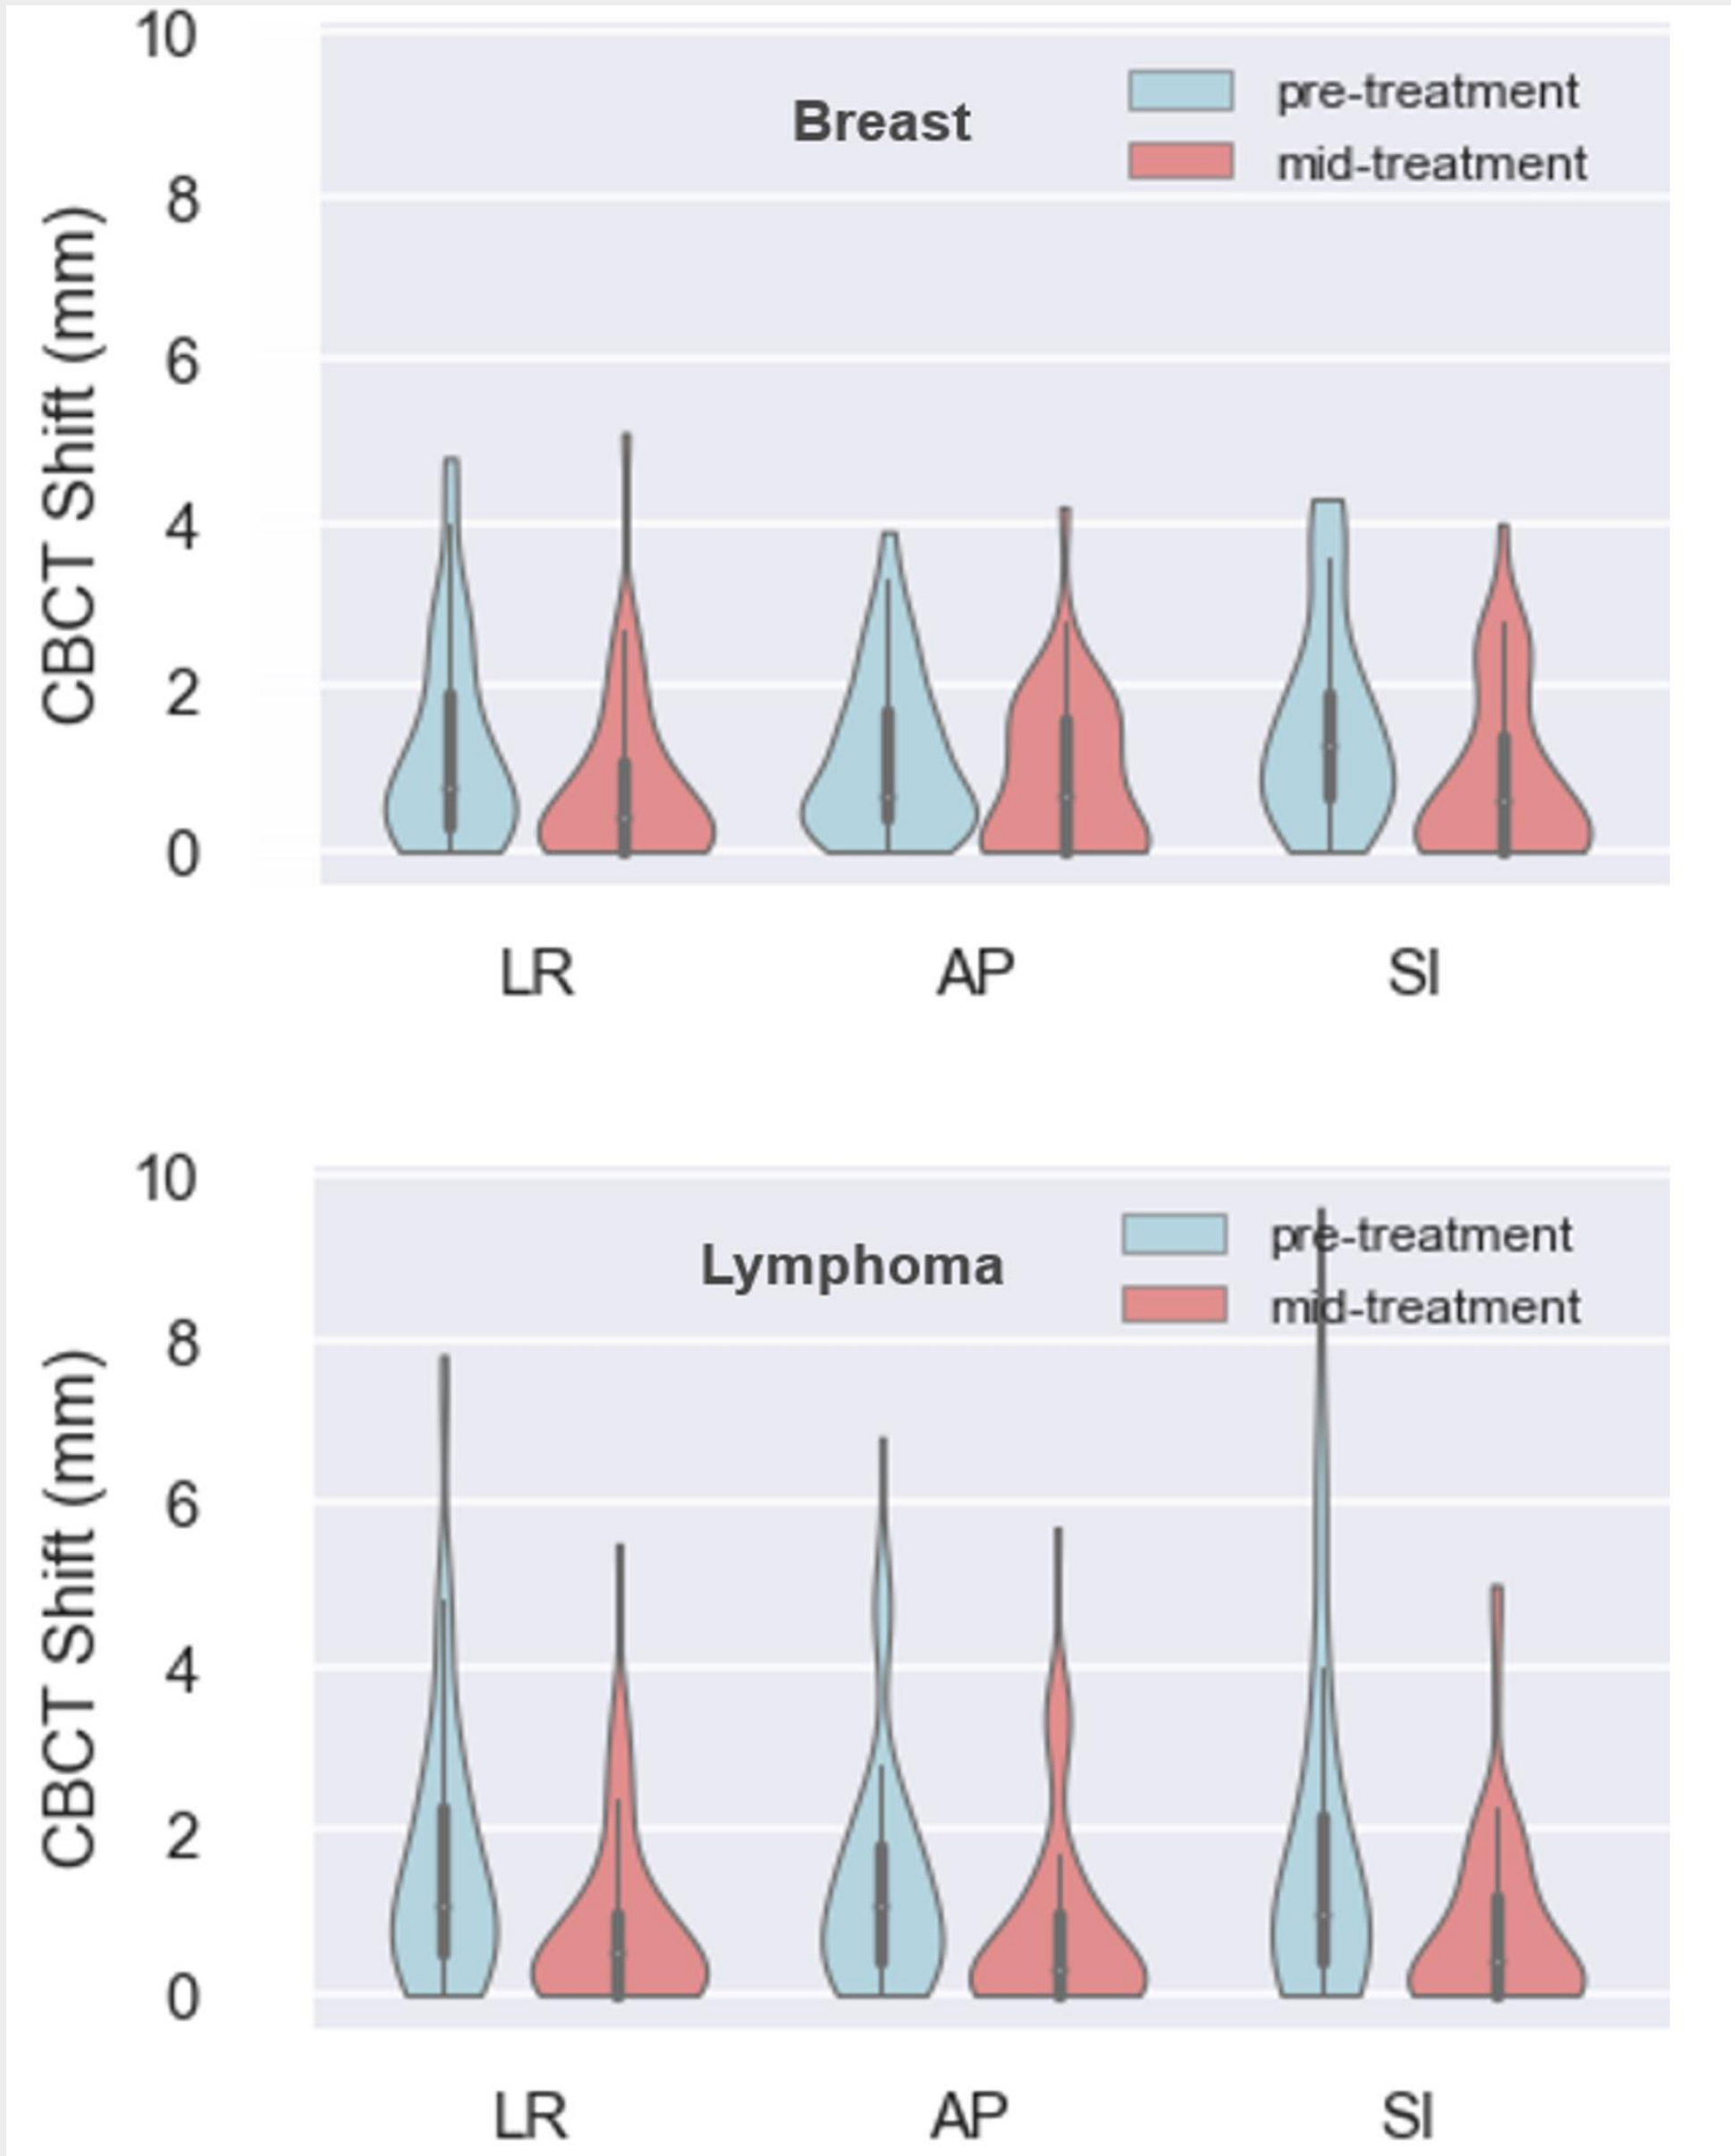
Pre-treatment and mid-treatment CBCT shifts during SGRT-guided BH for breast and abdominal lymphoma treatments.
